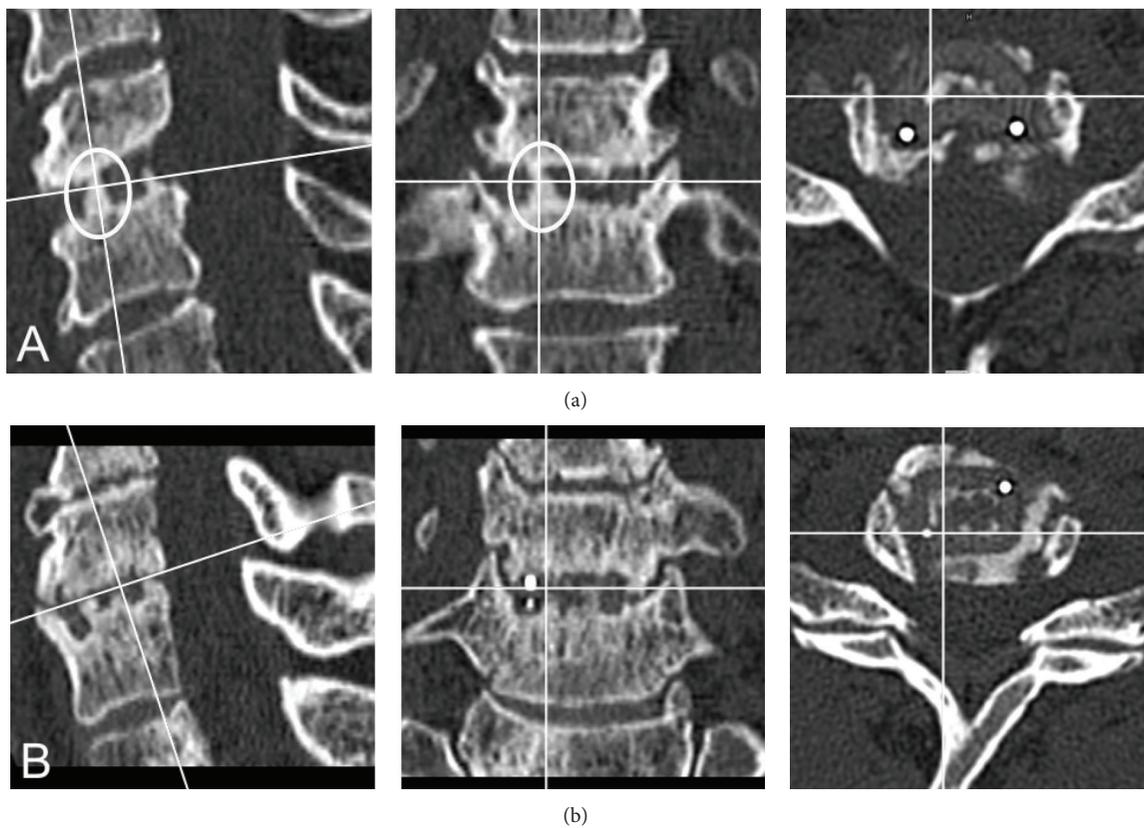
Fusion and nonfusion. Postoperative three-dimensional reconstructed CT scans after ACD with implantation of PEEK cages. (a) A continuous trabecular bone bridge through the cage (encircled) confirmed bony fusion; (b) no bony fusion was assessed due to the lack of continuous trabecular bone bridges.
